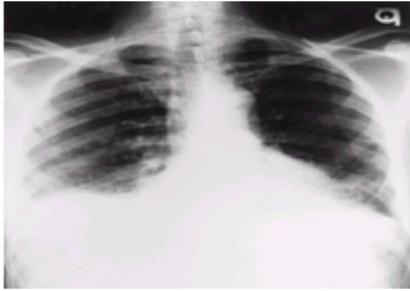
Chest radiograph from a patient with anti-Jo-1-positive polymyositis that shows severe interstitial fibrosis affecting predominantly the lower lobes.
